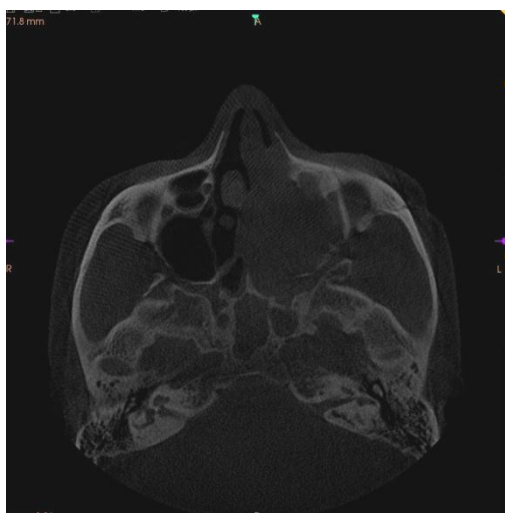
Axial section of CBCT.
